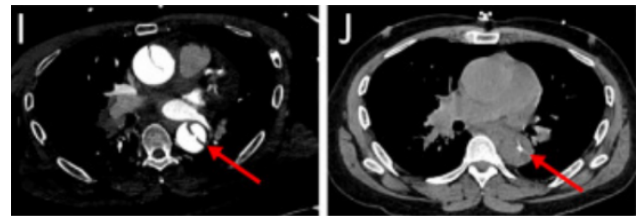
CT scans of type A AD with contrast (Image I) and type A AD without contrast (Image J) (Spangenberg et al., 2023).
